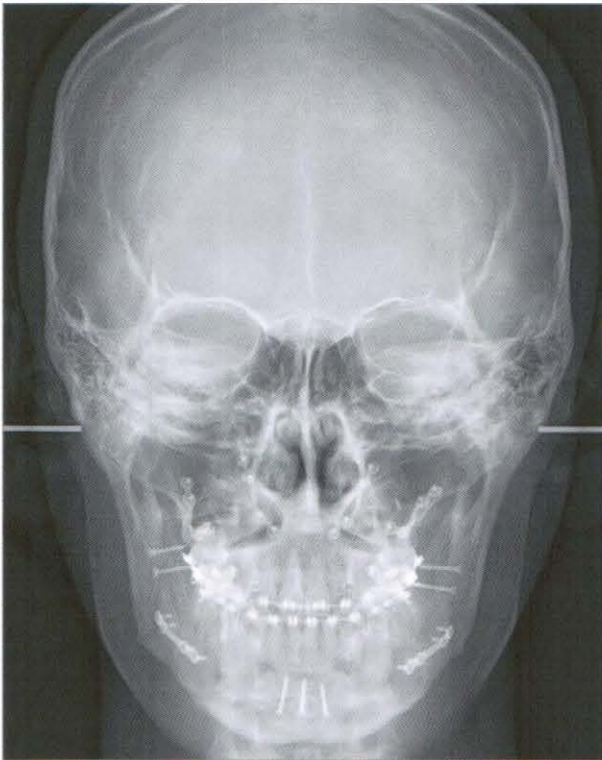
Postsurgical postero-anterior radiograph
